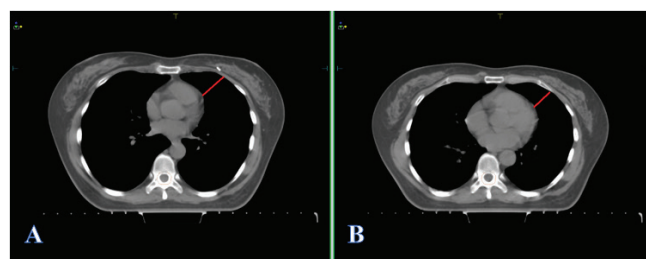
A) left: mDIBH / B) right: Free breathing. The CT scan (Figure A) shows a distance between the heart and the chest wall of 4.02 cm at mDIBH, while (Figure B) shows free breathing and a distance of 2.82 cm.
